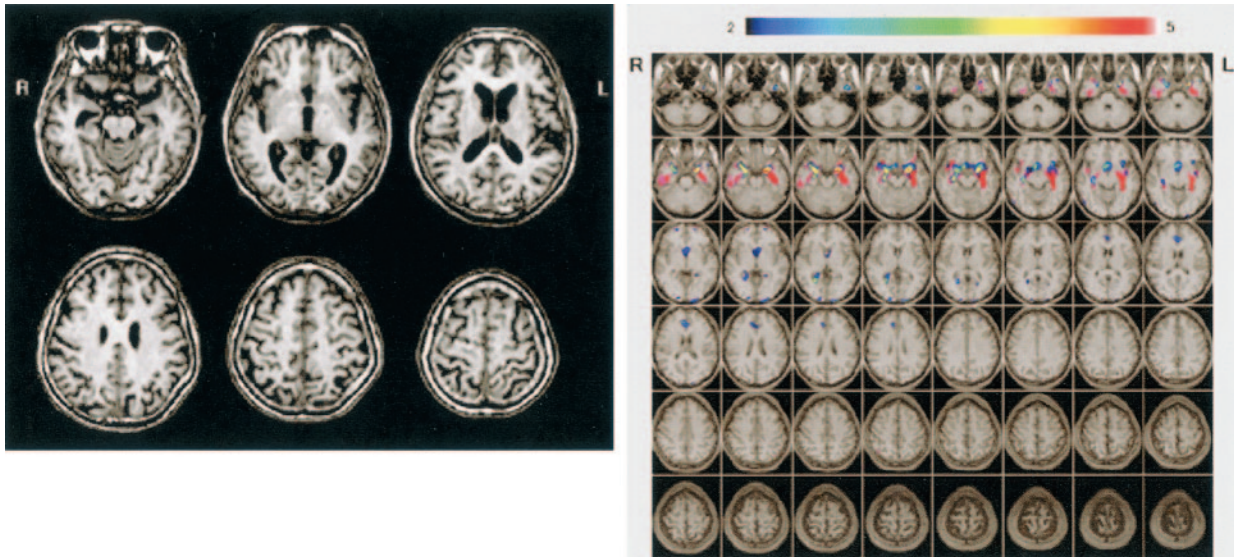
A and B, Conventional MR images (A) and Z score images (B) obtained in a 73-year-old patient with late-onset AD (MMSE score = 23). Medial temporal atrophy can be detected by visual inspection of the conventional T1-weighted images. By using the Z score map, the region and degree of atrophy can be detected easily; note that the left hippocampal atrophy is stronger than the right. L indicates left; R, right.
